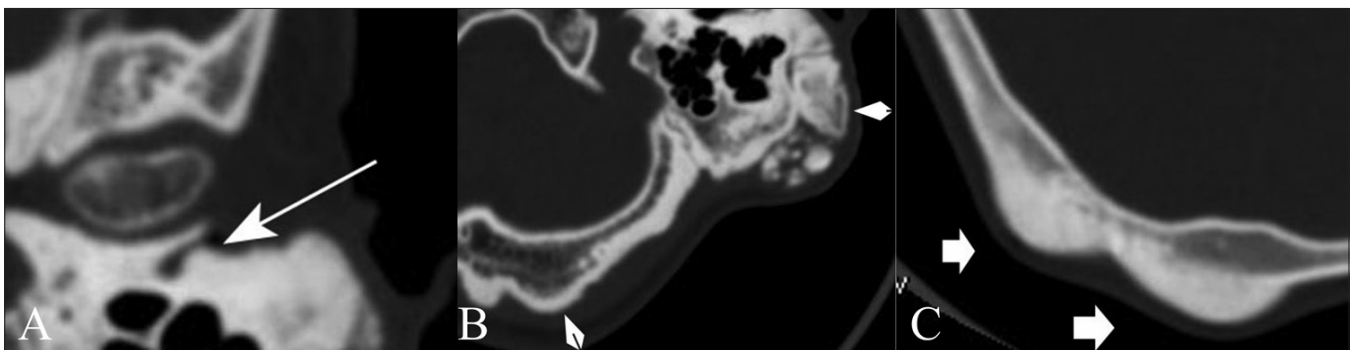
(A-C): EAC osteoma: axial HRCT image (A) shows an osteoma arising from the posterior wall of the EAC. Axial CT scans in bone windows (B, C) show multiple osteomas (arrowheads) of the skull
